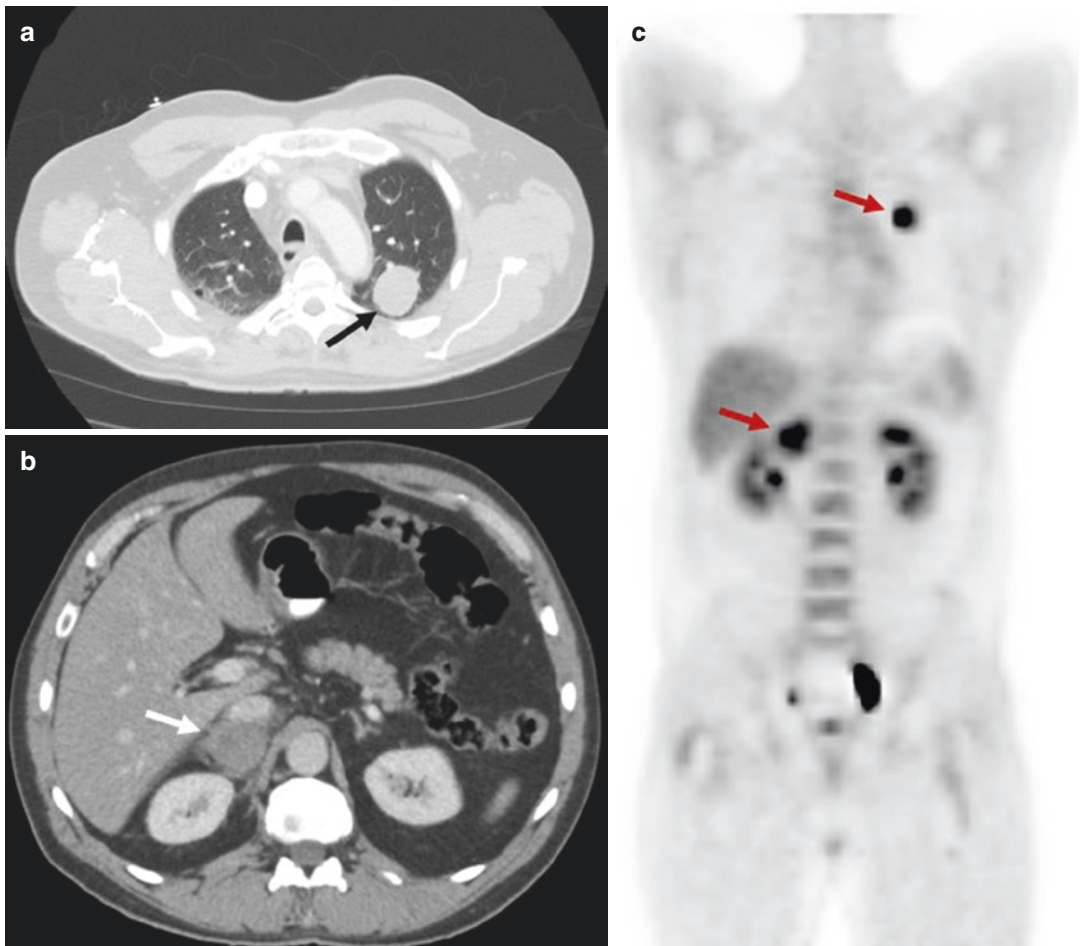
A 54-year-old man with BRAF-negative histiocytic sarcoma. (a) Contrast-enhanced axial CT image of the chest demonstrates a well-defined round mass in the left upper lobe (*black arrow*). (b) Axial CT image of the upper abdomen obtained during portal venous phase shows a rounded left adrenal hypo-enhancing mass
